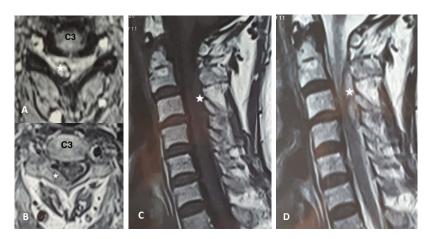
MRI of SSEH appeared epidural hematoma at the C2-C4 level (star), and revealed heterogeneous hyperintense on T2W image (A, D), homogeneous isointense on T1W image (C), and non-enhancing of the SSEH on T1W with contrast (B).
